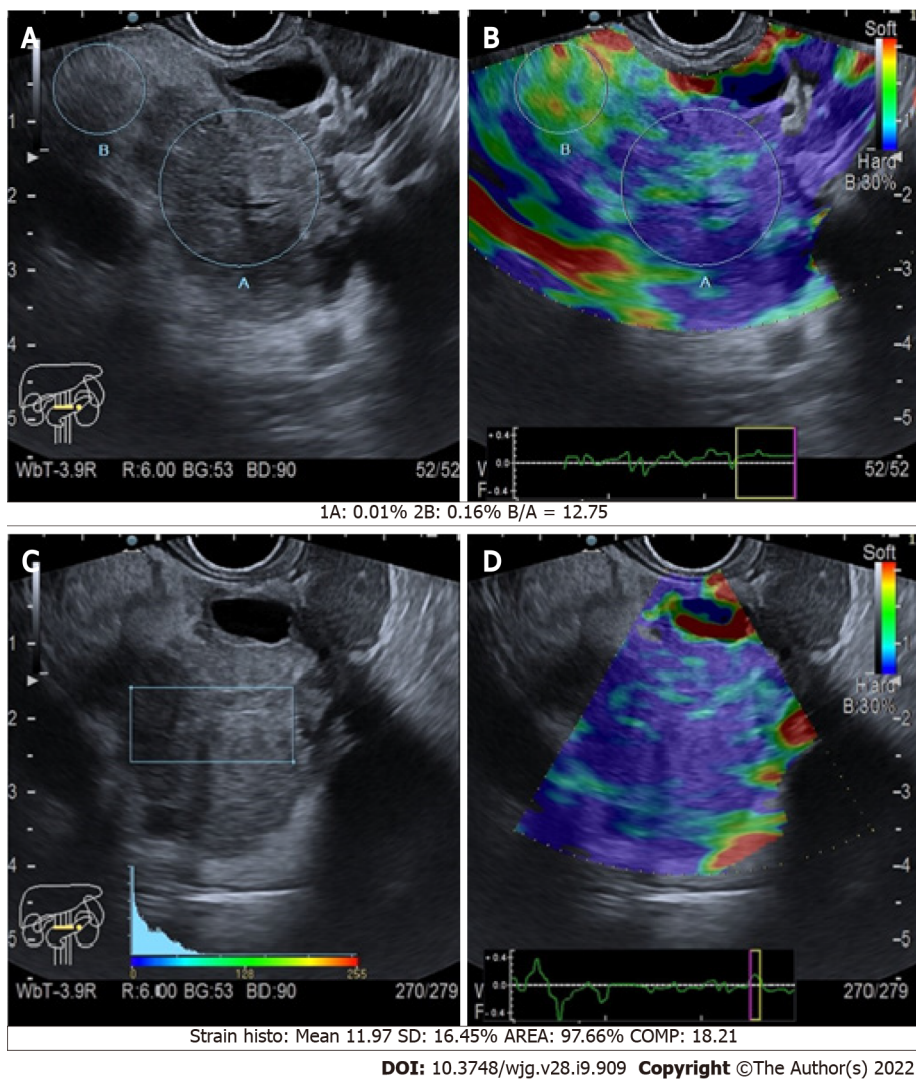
Quantitative endoscopic ultrasound elastography of pancreatic cancers of the body. A and C: B-mode with region of interest circles and square; B and D: Elastographic images.
